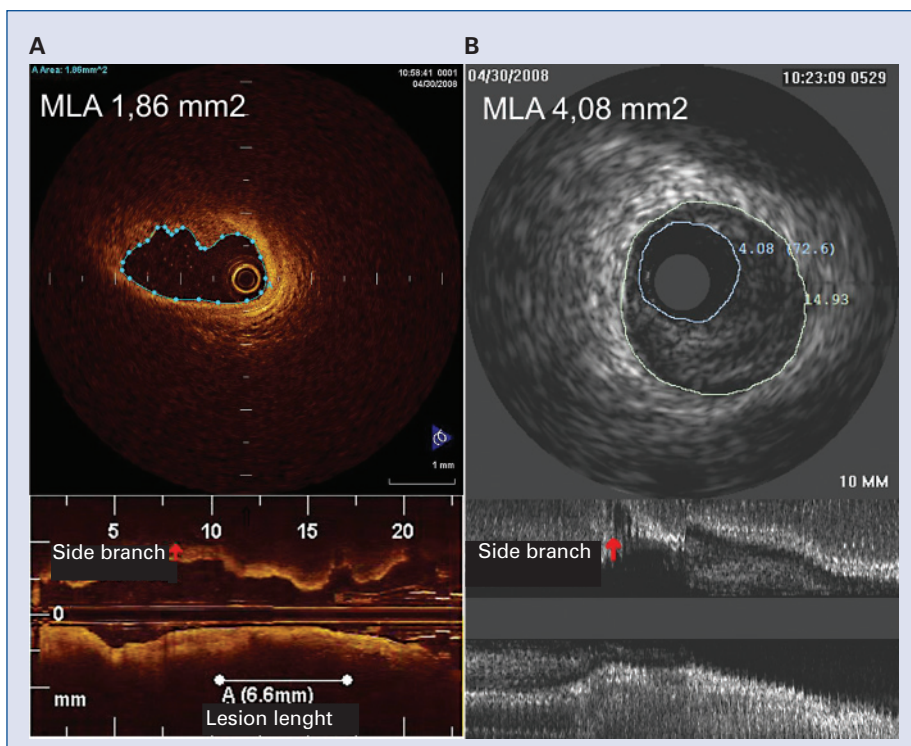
Cross-section of the left anterior descending coronary artery at the site of minimal lumen area. Optical coherence tomography showed significantly smaller minimal lumen area (1.86 mm²; A) compared to intravascular ultrasound (4.08 mm²; B). Intravascular ultrasound underestimated minimal lumen area due to its inability to visualize soft structures corresponding to intraluminal thrombus.
